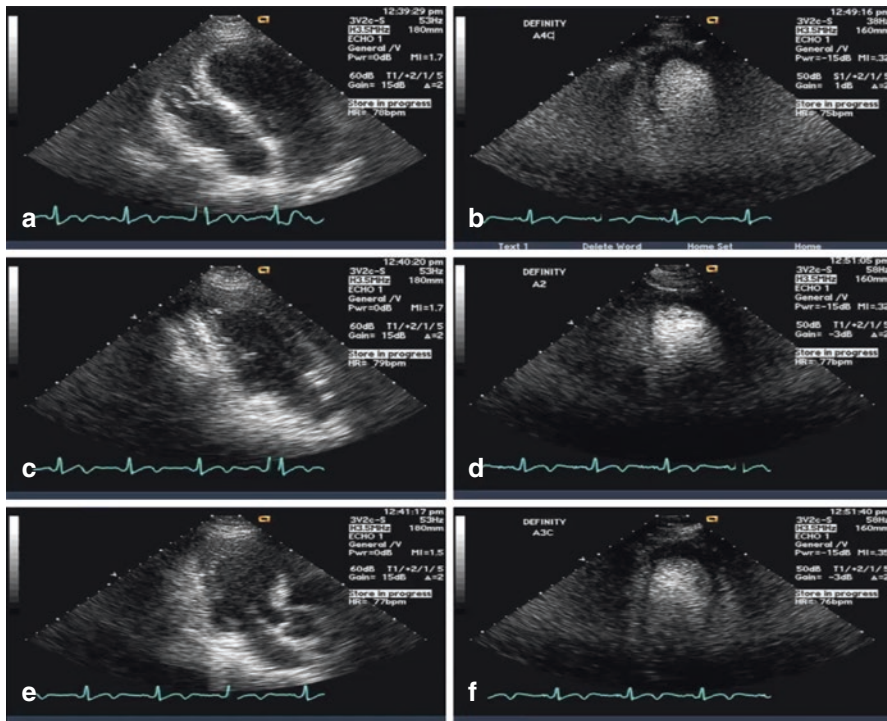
Comparison between unenhanced (a) and contrast-enhanced (b) apical four-chamber views as well as unenhanced (c) and contrast-enhanced (d) apical two-chamber views and unenhanced (e) and contrast-enhanced (f) apical long-axis view
